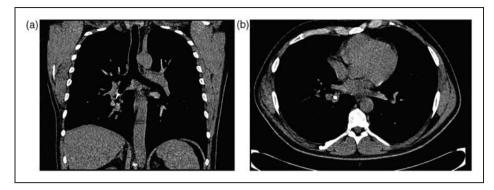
(a) HRCT (coronal) six months before the operation showing the traffic cone occluding the right bronchus intermedius. (b) HRCT (axial) six months before the operation showing the traffic cone occluding the right bronchus intermedius.
